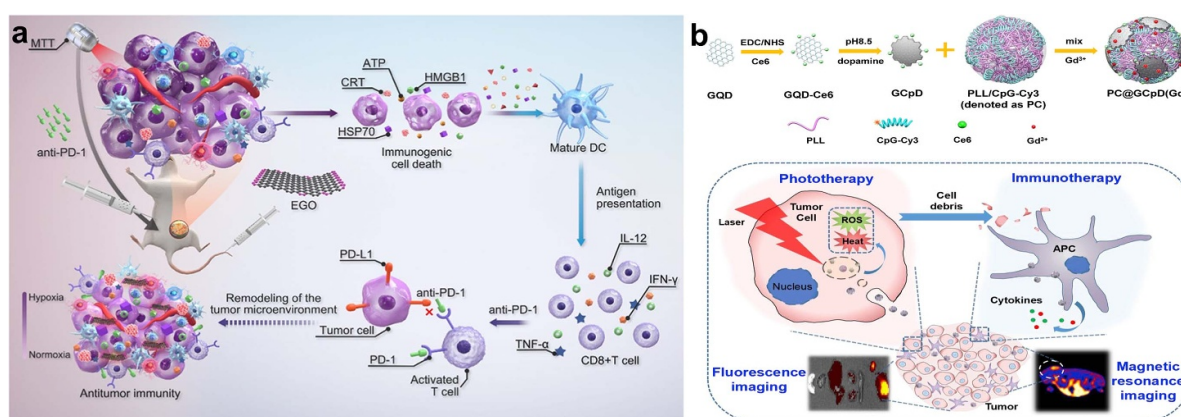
(a) Edge oxidized graphene based thermal immunotherapy for tumor microenvironment reprogramming. Reprinted with permission from [277]. Copyright (2024) American Chemical Society. (b) Mechanism of MRI/FI bimodal photo-immunotherapy facilitated by PC@GCPD(Gd). Reprinted from [280], Copyright (2019), with permission from Elsevier.
